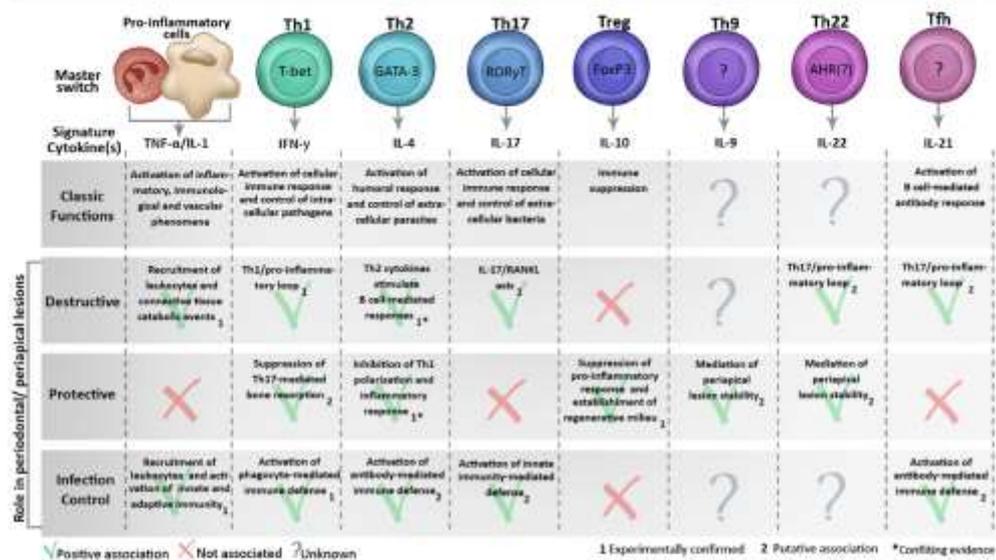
Defining features of pro-inflammatory and T lymphocyte helper cell subsets in periodontal and periapical lesions. Pro-inflammatory and T lymphocyte helper cell subsets present characteristic features (such as master switches, signature cytokines and classic functions) that define
